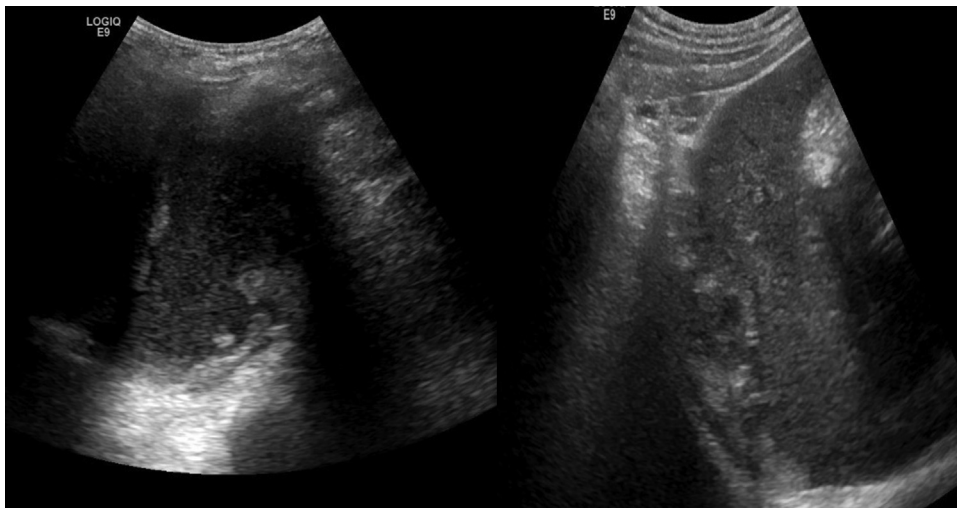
Ultrasound-guided placement of a 10F catheter into the fluid collection. A 7-mm echogenic lesion in the dependent aspect of the collection was visualized suspicious for a dropped gallstone.
